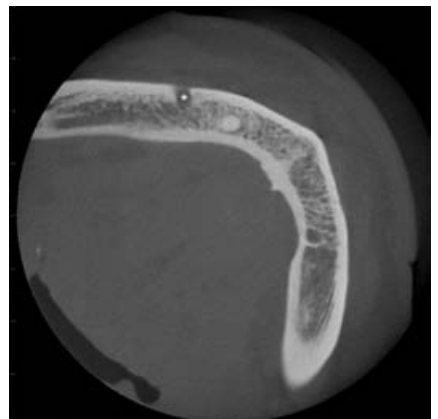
Axial CBCT image with mental foramen (*)
